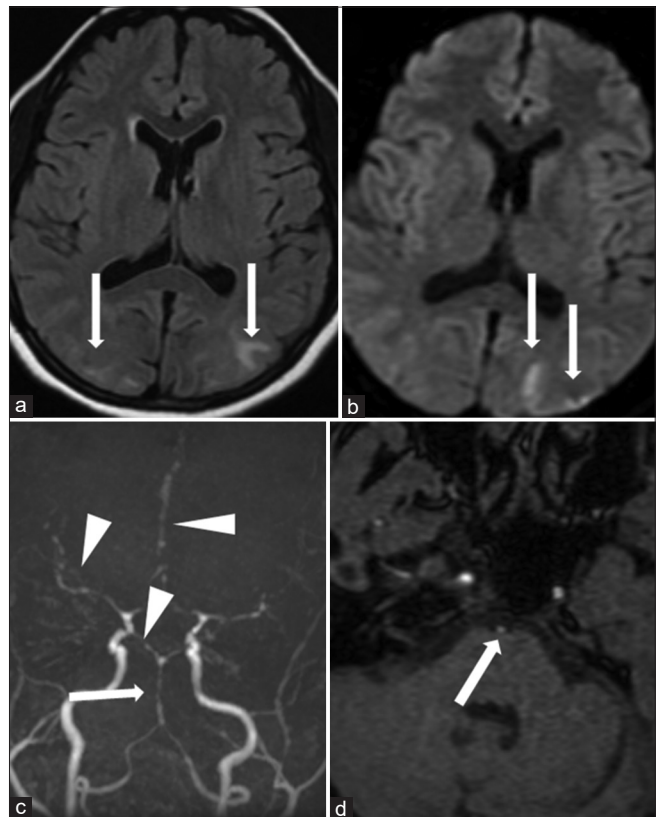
Reversible cerebral vasoconstriction syndrome. MRI brain of a 21-year-old female with the complaints of acute headache and blurred vision shows patchy areas of T2 fluid-attenuated inversion (FLAIR) hyperintensity in the bilateral occipital lobes (arrows in a), with few of them showing diffusion restriction (arrows in b); 3D TOF images shows diffuse thinning and beading of the basilar artery (arrow in c and d), and all the cerebral arteries (arrowheads in c). The patient was treated with antiepileptic and steroids and showed improvement.
